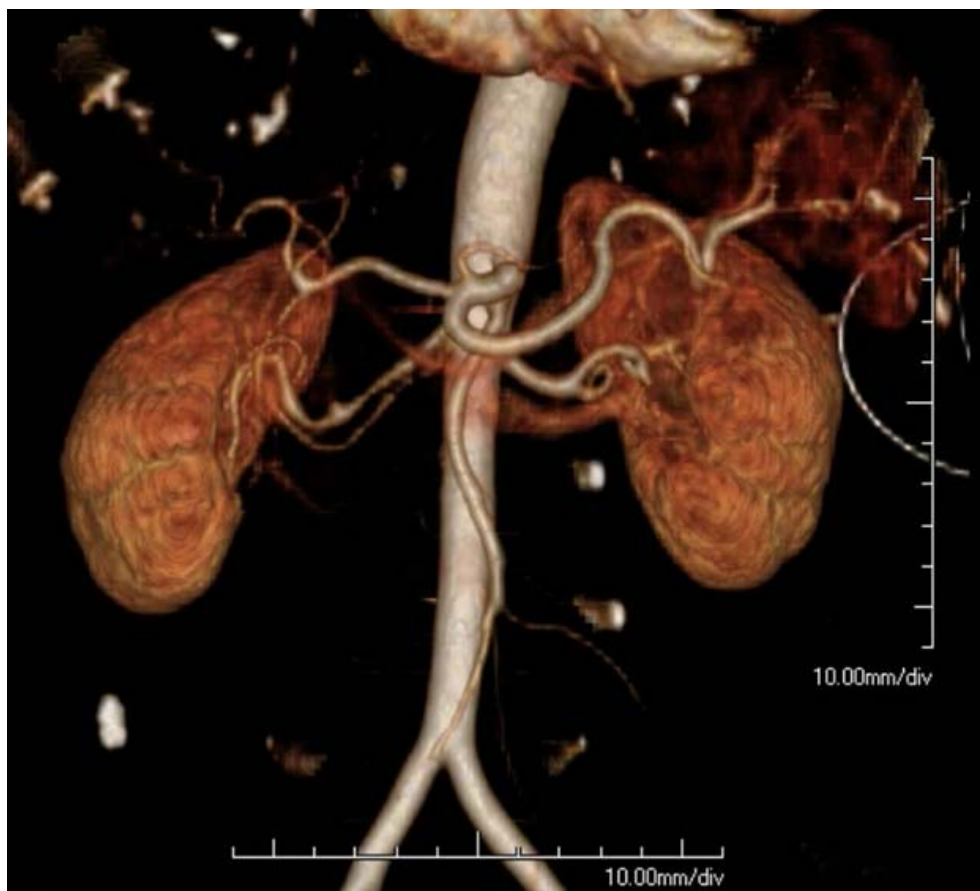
CTA abdomen with 3D reconstruction shows right renal artery aneurysm
